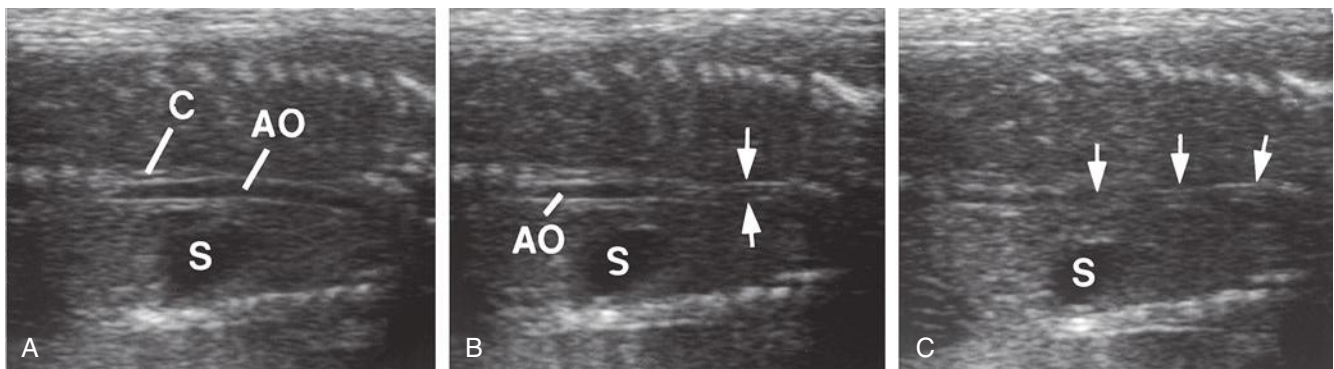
Coronal sonograms depicting the mid- and distal esophagus. First (A), the descending aorta (AO) is localized. B and C, As the transducer is moved anteriorly, the esophagus (arrows) comes into view. C, diaphragmatic crura; S, stomach.
